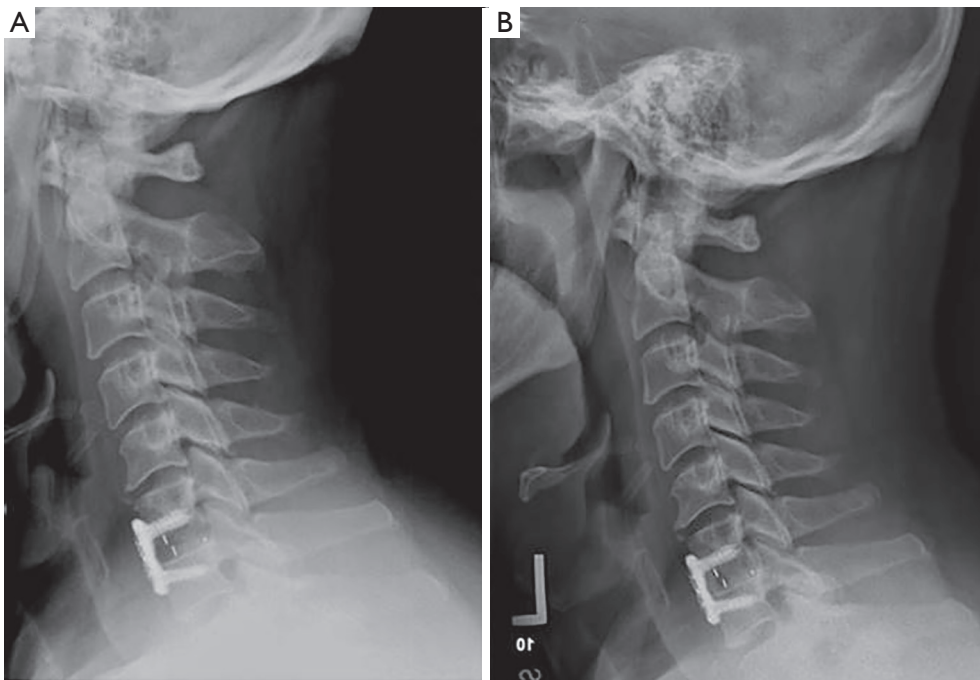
Radiographs of a C5/6 ACDF using an allograft spacer at 6 weeks (A). At 2 years there is bridging bone and no subsidence, indicating a robust fusion (B). ACDF, anterior cervical discectomy and fusion.
